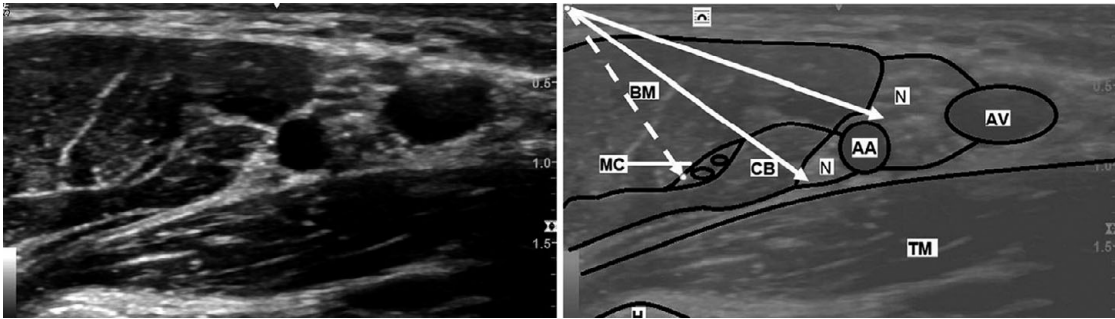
Ultrasound appearances of the brachial plexus in the axillary region showing axillary artery (AA), axillary vein (AV), biceps muscle (BM), musculocutaneous nerve (MC), coracobrachialis muscle (CB), triceps muscle (TM), humerus (H) and radial, median and ulnar nerves (N).
